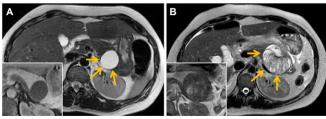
MRI scan showing the cystic lesion in the (a.) pancreatic tail at presentation and (b.) three years earlier.
